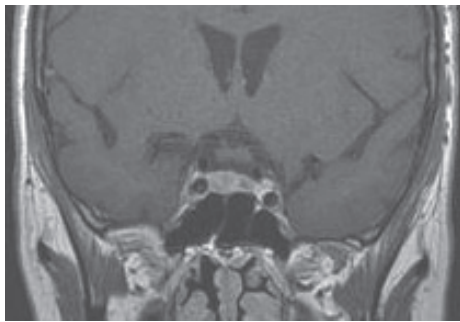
Coronal pituitary MRI after gadolinium showing an asymmetric pituitary gland with a contrast-enhanced microadenoma on the left and an inhomogeneous area on the right side of the gland.
